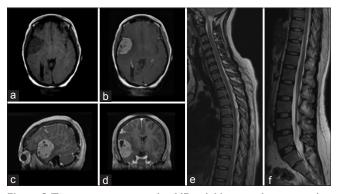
Two year post operative MR axial images demonstrating T1 weighted a non enhancing fronto-temporal mass (a), with hyperintensity following gadolinium enhancement on T1-weighted axial (b), sagittal (c) and coronal views (d). Images demonstrating the absence of drop metastases or other enhancing lesions T1-weighted gadolinium enhanced images of thoracic (e), and lumbar (f) spinal cord
